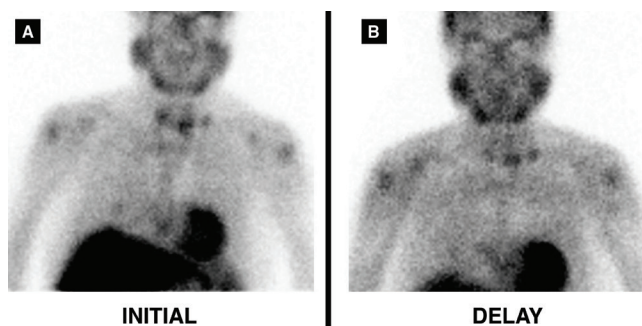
The patient underwent parathyroid scintigraphy for detecting a parathyroid focus, after injection of 740 MBq (20 mCi) MIBI. Three focal MIBI uptakes in the low cervical region were considered as functional parathyroid carcinoma recurrence (A and B). These functional lesions were embolized percutaneously with 95% alcohol under ultrasound guidance in two sessions with an amount of 0.8 cc and 1.5 cc, respectively, by an interventional radiologist experienced in ultrasound guided procedures
